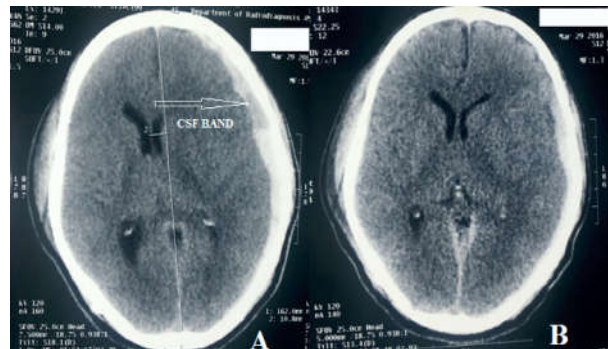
Case no 7. (A) Initial CT head having left side acute SDH and CSF band (arrow), (B) Repeat CT head of showing rapid spontaneous resolution of SDH
